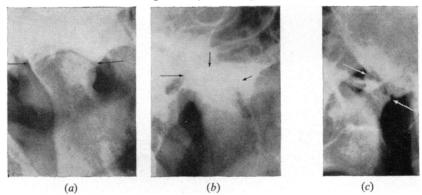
X-ray appearance of ankylosed condyles, (a) old Still's disease (rheumatoid arthritis) with mushrooming of heads of condyle; (b) psoriatic arthritis with dense sclerosis; (c) fibrous ankylosis following infection showing line of cleavage.
